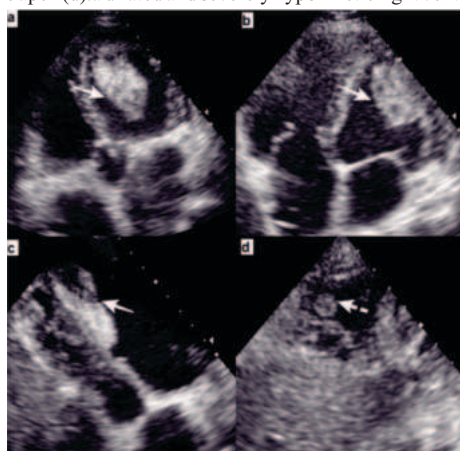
2D-trans-thoracic echocardiography in parasternal and short-axis views demonstrated two echo-dense masses attached to the infero-septal and antero-lateral segments of the left ventricle and grossly dilated left ventricle (LV).
